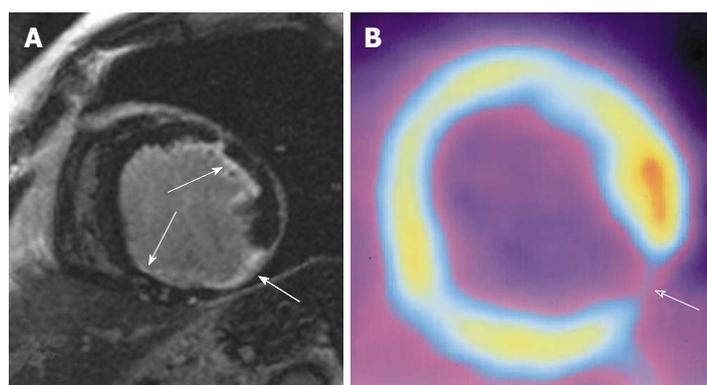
A sixty-seven-year-old man with severe coronary artery disease and history of myocardial infarction. A: Short axis inversion-recovery gradient-recalled echo cardiac magnetic resonance imaging (CMR) image of the mid- to apical-portion of the left ventricular shows a small area of transmural late gadolinium enhancement (LGE) in the inferolateral wall (broad arrow). CMR viability scores: Anterior: 2; anterolateral: 2; inferolateral: 4; inferior: 2; B: The positron emission tomography (PET) image of the corresponding slice reveals an uptake defect (broad arrow) in the same segment suggesting a transmural scar. PET viability scores: anterior: 2; inferolateral: 4. Small subendocardial scars with LGE in CMR (A) in the anterolateral and inferior wall (small arrows) were overseen in PET.
